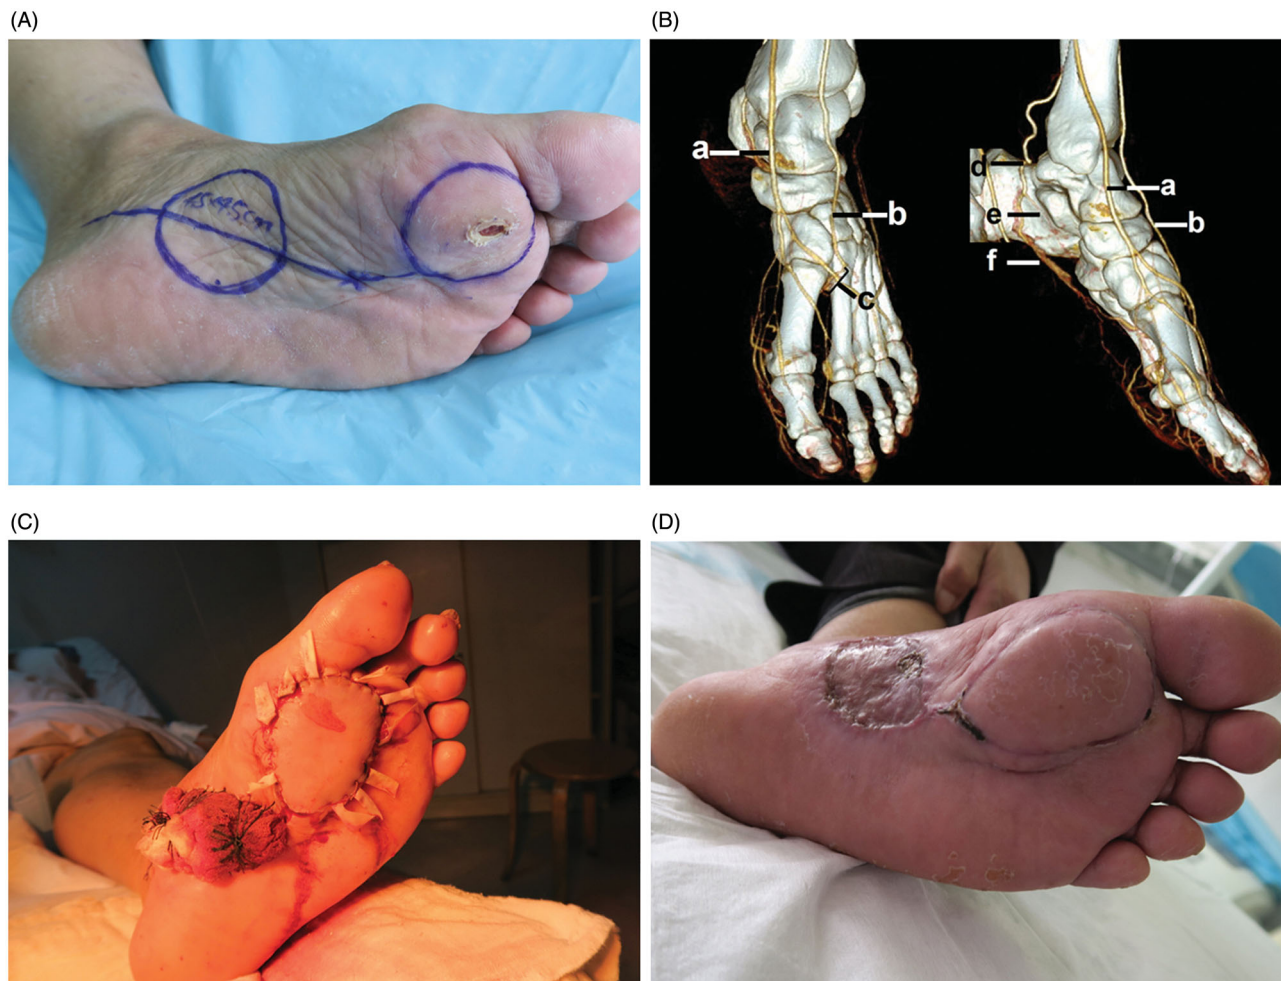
Typical case 1. (A) A 65-year-old man had a melanoma in the left forefoot sole. The design of reverse medial plantar flap was showed. (B) Computed tomography angiography scan showed the dorsalis pedis artery to the deep plantar arch, posterior tibial artery, and medial and lateral plantar arteries: (a) great saphenous vein; (b) dorsalis pedis artery; (c) deep branch of dorsal pedis artery to plantar; (d) posterior tibial artery; (e) medial plantar artery; (f) lateral plantar artery. (C) A 4.5×4.5 cm medial plantar flap was raised and transferred to repair the defect. (D) The flap had an excellent aesthetic appearance and functional recovery without any donor site deformity.
